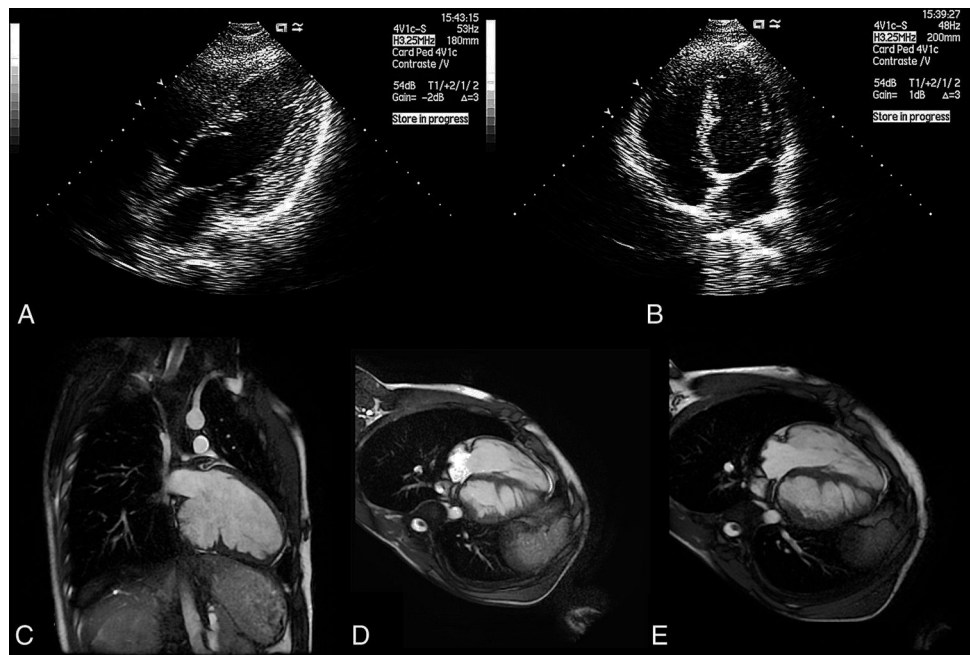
Two-dimensional transthoracic echocardiography in modified 4-chamber view showing echodense myocardial projections with sawtooth morphology (A and B); cardiac magnetic resonance imaging in 2-chamber long-axis view showing projections of apparently compacted myocardium originating from the left ventricular inferior wall (C); cardiac magnetic resonance imaging in axial 4-chamber view showing projections of apparently compacted myocardium originating from the left ventricular inferior wall and the left side of the interventricular septum (D and E).
